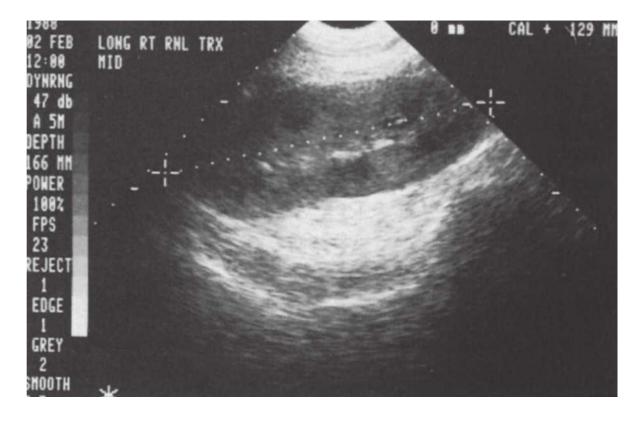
Anormal renal ultrasound of a transplanted kidney.
